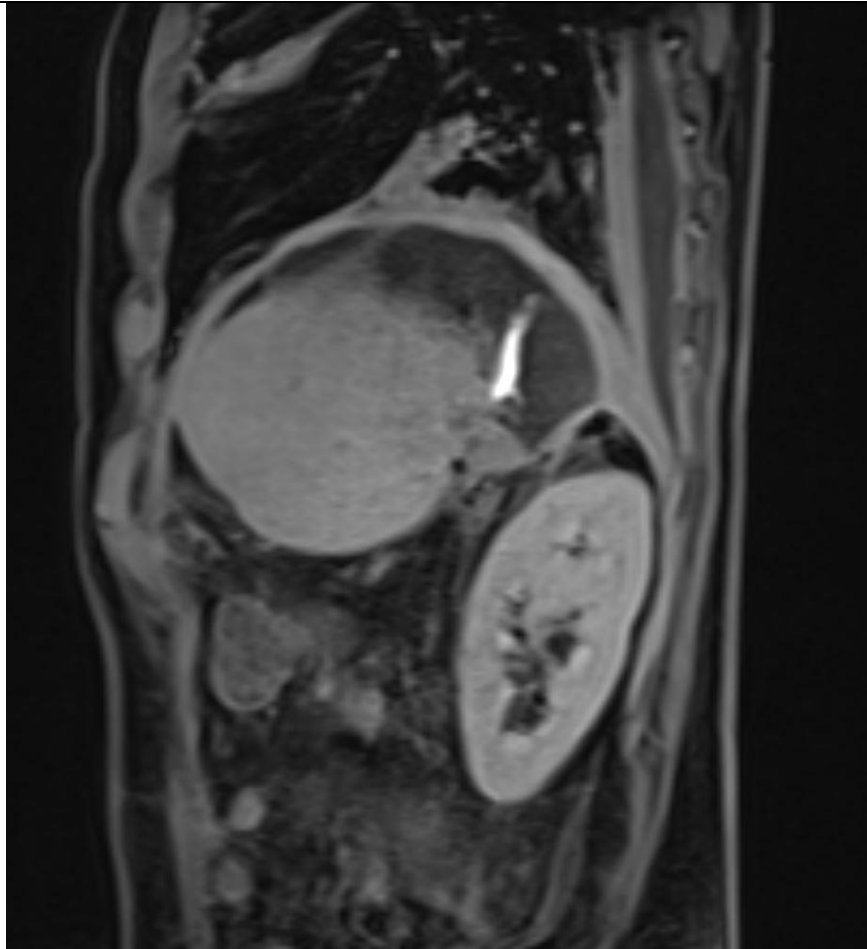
Cholangio- MRI sagittal fat sat (2) and axial fat sat (3) T1w with epatospecific contrast show biliary leakage and fistula with spreading of contrast close to surgical margins.
